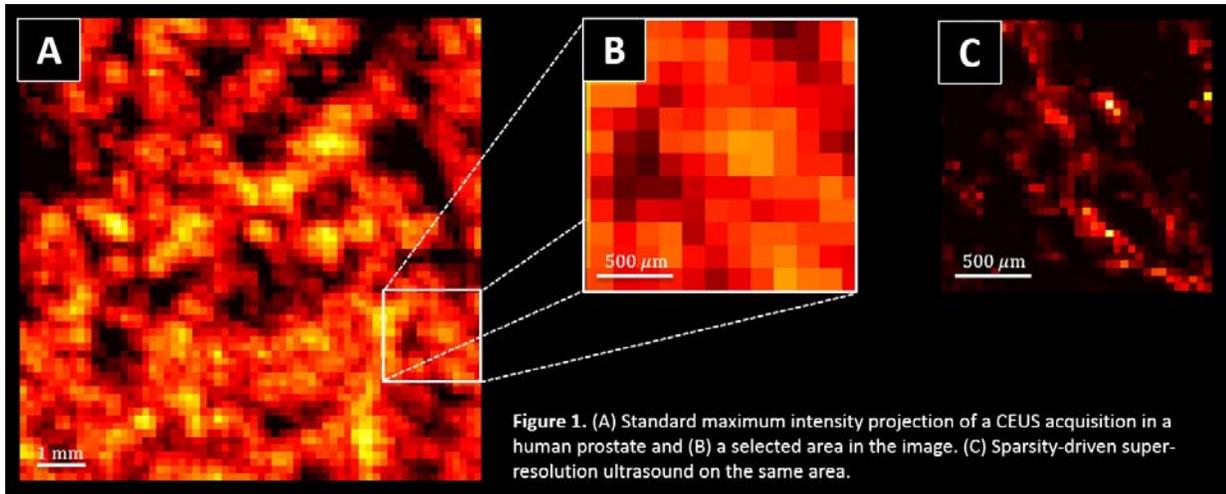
(A) Standard maximum intensity projection of a CEUS acquisition in a human prostate and (B) a selected area in the image. (C) Sparsity-driven super-resolution ultrasound on the same area.
